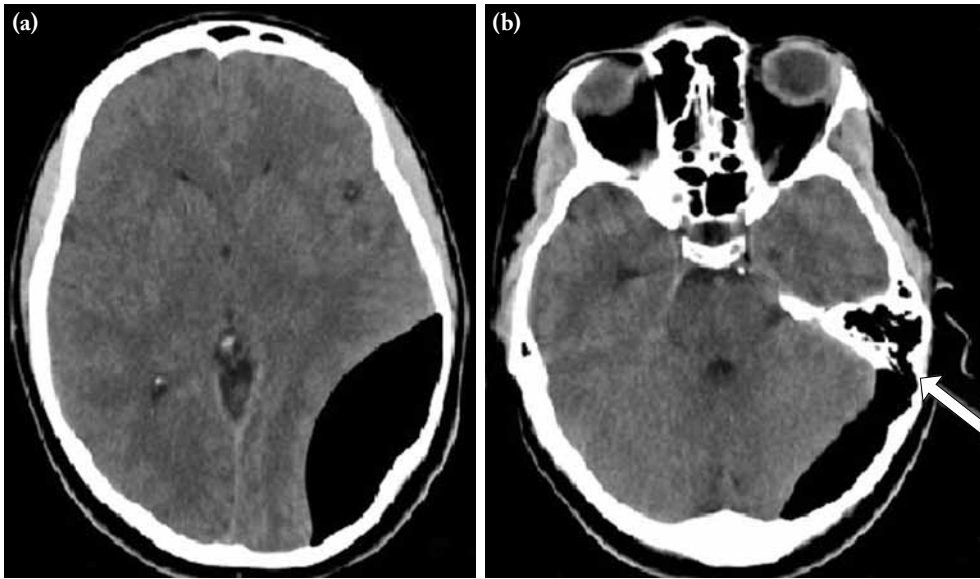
(a, b) Cranial non-enhanced computed tomography shows epidural air in the left parietal convexity and retro-cerebellum. There are connections between the left mastoid cavity and epidural air (arrow).
